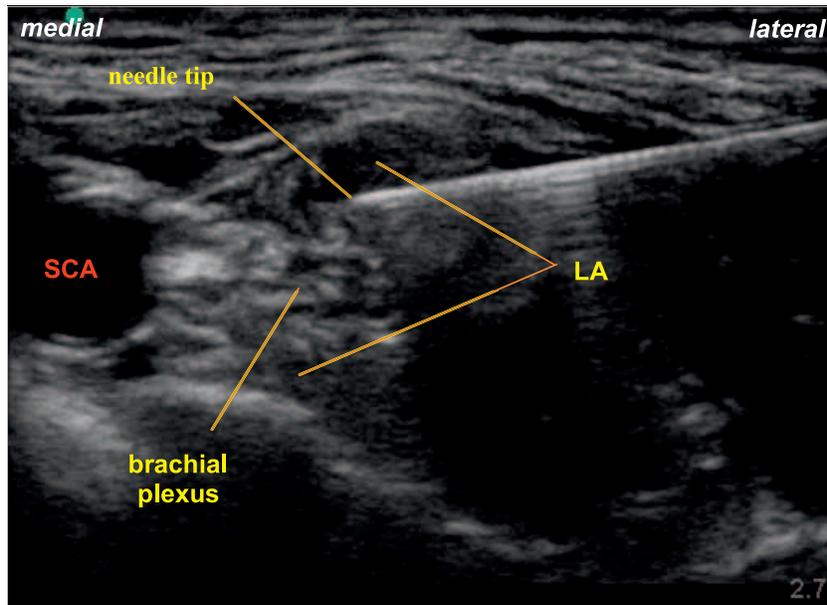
In-plane ultrasound image demonstrating the needle redirected to the superficial aspect of the plexus and the brachial plexus surrounded by local anaesthetic.
